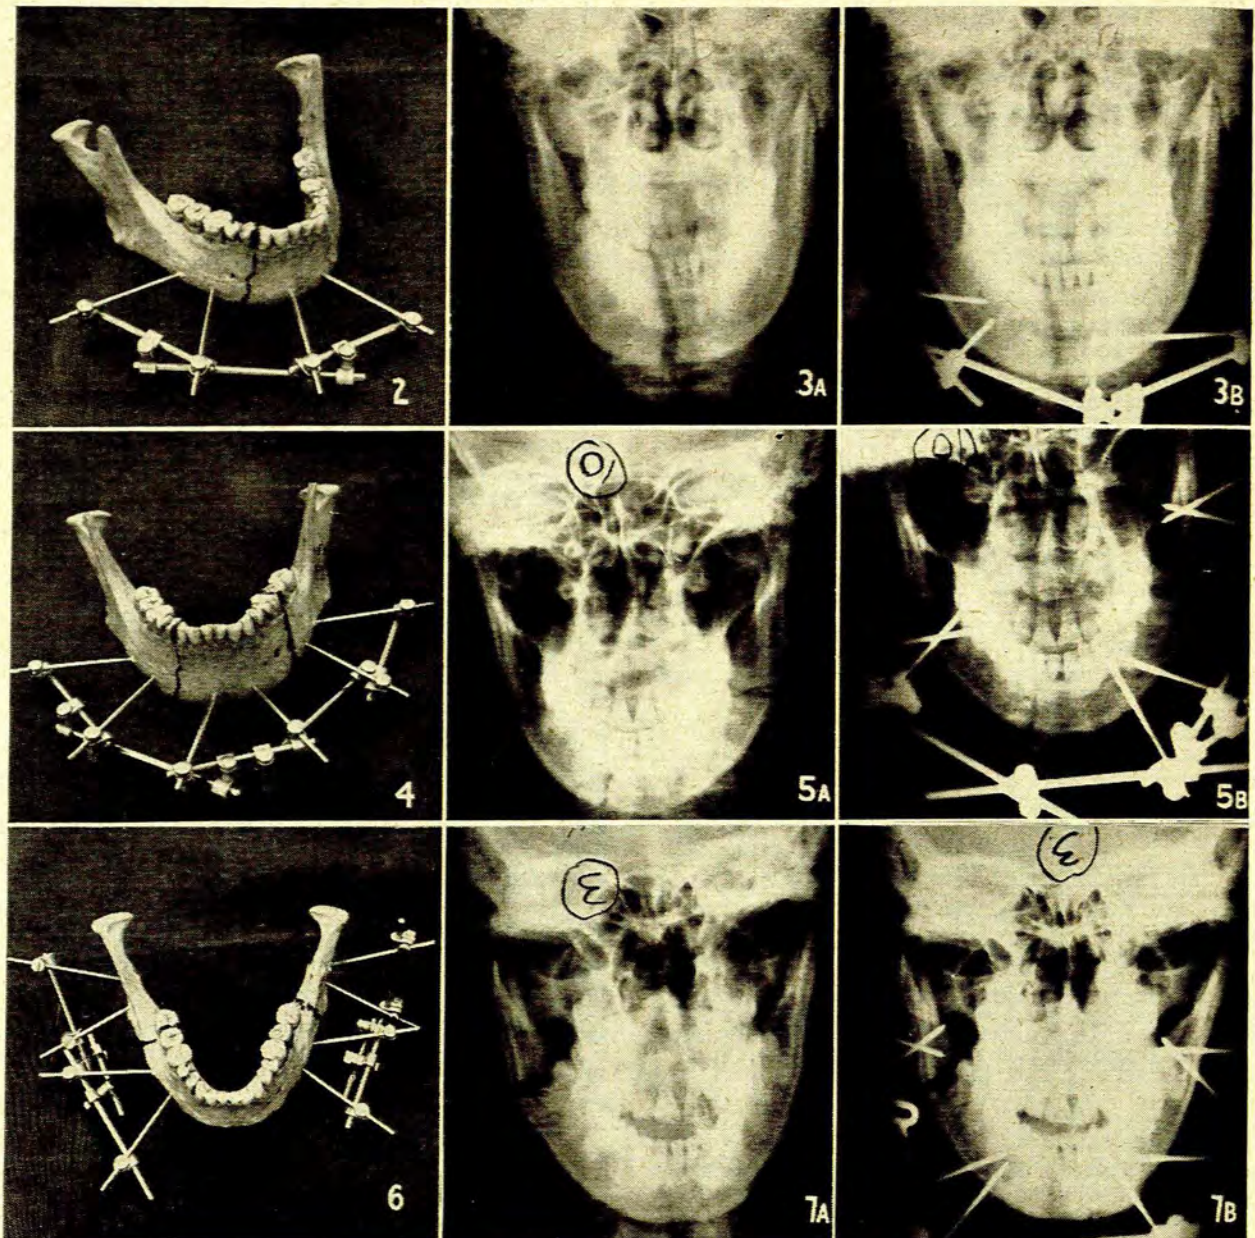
Use of external fixation apparatus for single mandibular fracture. Figs. 3A and 3B. X-rays of single fracture of mandible without and with external fixation. Fig. 4. Use of external fixation apparatus for a double mandibular fracture, 3 universal sets being utilized. Figs. 5A and 5B. X-rays showing double mandibular fractures with and without external fixation. Fig. 6. Widely separated double mandibular fractures requiring four universal sets. Figs. 7A and 7B. X-rays of widely separated double mandibular fractures with and without external fixation.
